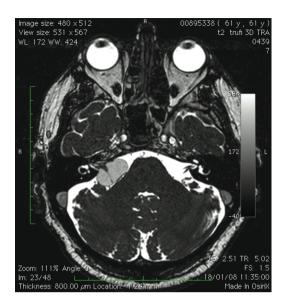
MRI axial scan T2-weighted showing a cystic vestibular schwannoma. The cystic component is the prevalent portion displayed with an intermediate gray due to difference in proteins content compared to cerebrospinal fluid.
